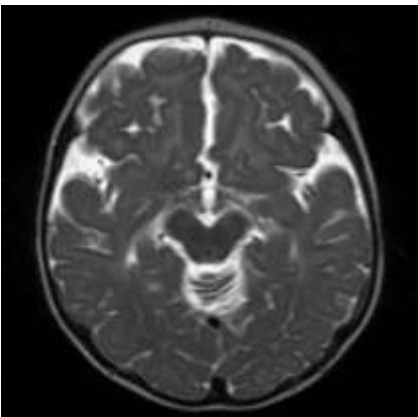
The brain MRI of the individual V-1 (without contrast): Brain atrophy is notable. The corpus callosum is hypoplastic.
